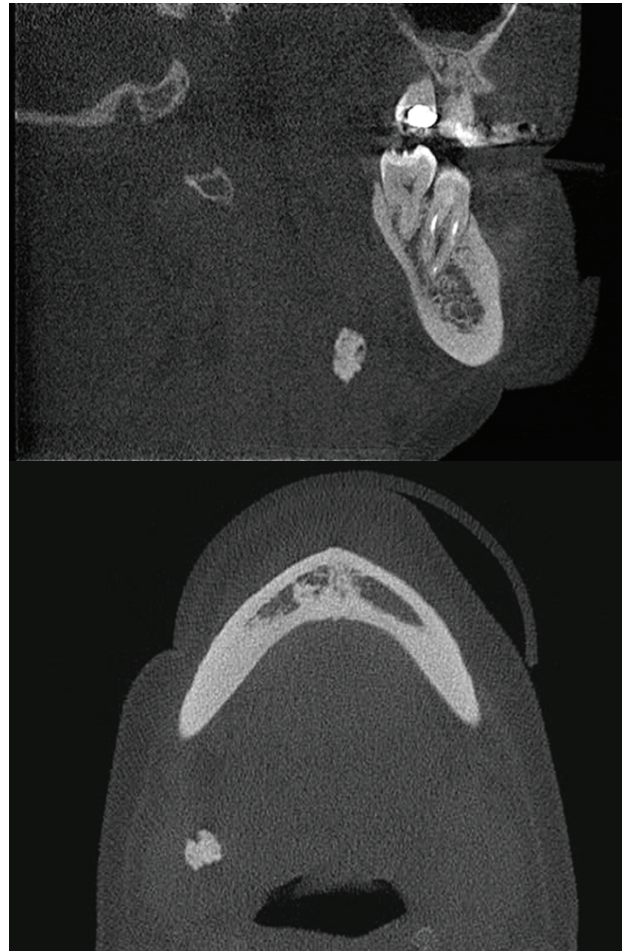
Sagittal views (A) and axial views (B) of the cone beam computed tomography showing the calcified lymph nodes.
